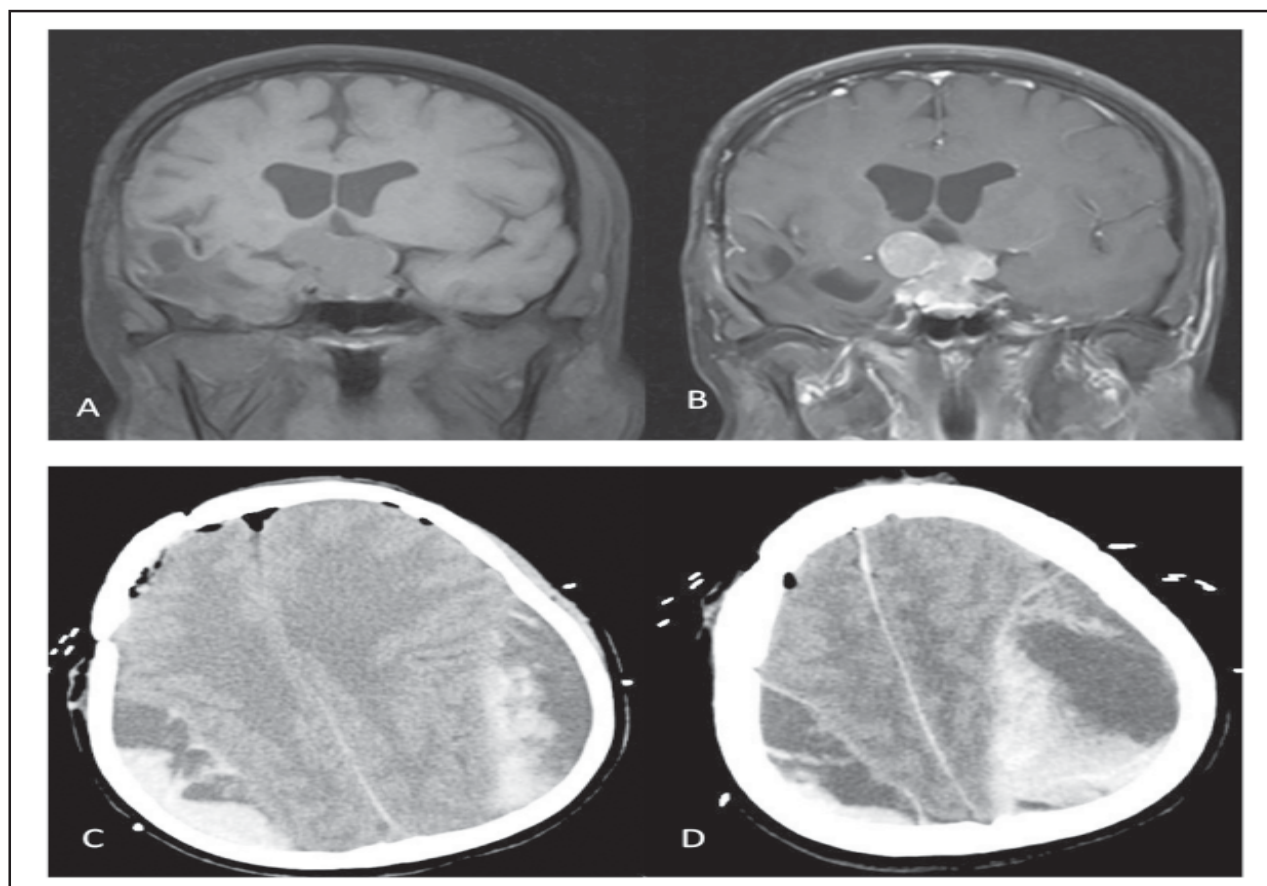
A-B: Preoperative MRI images showing a meningioma in the sellar region with uniform enhancement of the meningioma.
